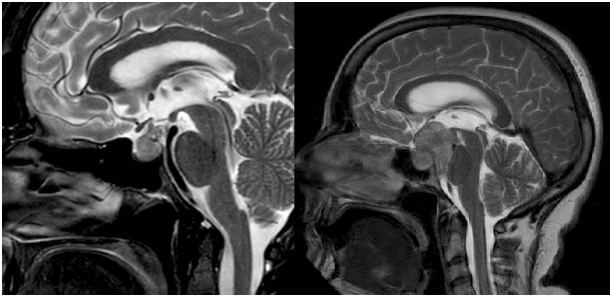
In order: first study during diagnostic process, second picture — 5 months after first magnetic resonance imaging (MRI)
